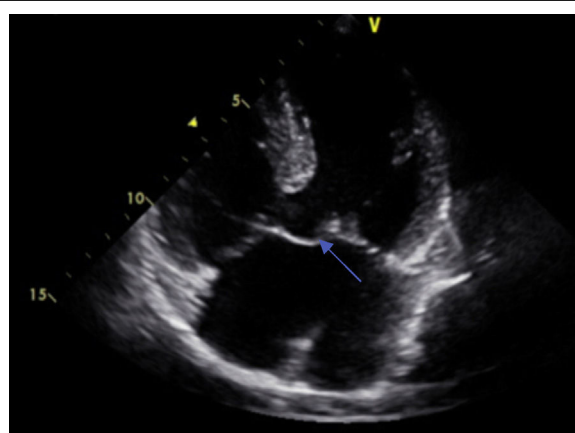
Echocardiography: a single atrioventricular valve (arrow).
